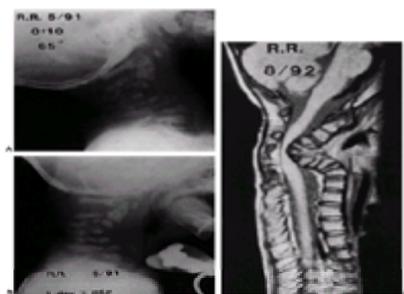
Larsen syndrome. A: Lateral radiograph of a 10-month-old patient showing kyphosis of 65 degrees, with correction to only 48 degrees in extension. B: Lateral radiograph immediately after posterior arthrodesis, showing patient with orthosis and correction of kyphosis to 39 degrees. C: T2-weighted magnetic resonance image 15 months postoperatively shows severe impingement on spinal cord. Kyphosis had progressed to 110 degrees, and patient was quadriplegic after a fall. (From ref. 239, with permission.)
